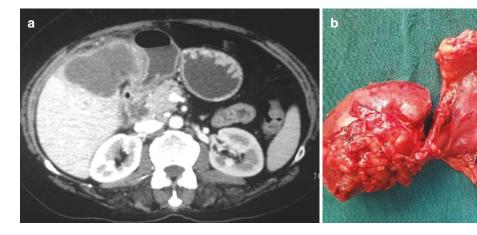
CT shows gall bladder cancer involving the pyloric antrum—this may require distal gastrectomy; (b) Extended cholecystectomy with distal gastrectomy for
